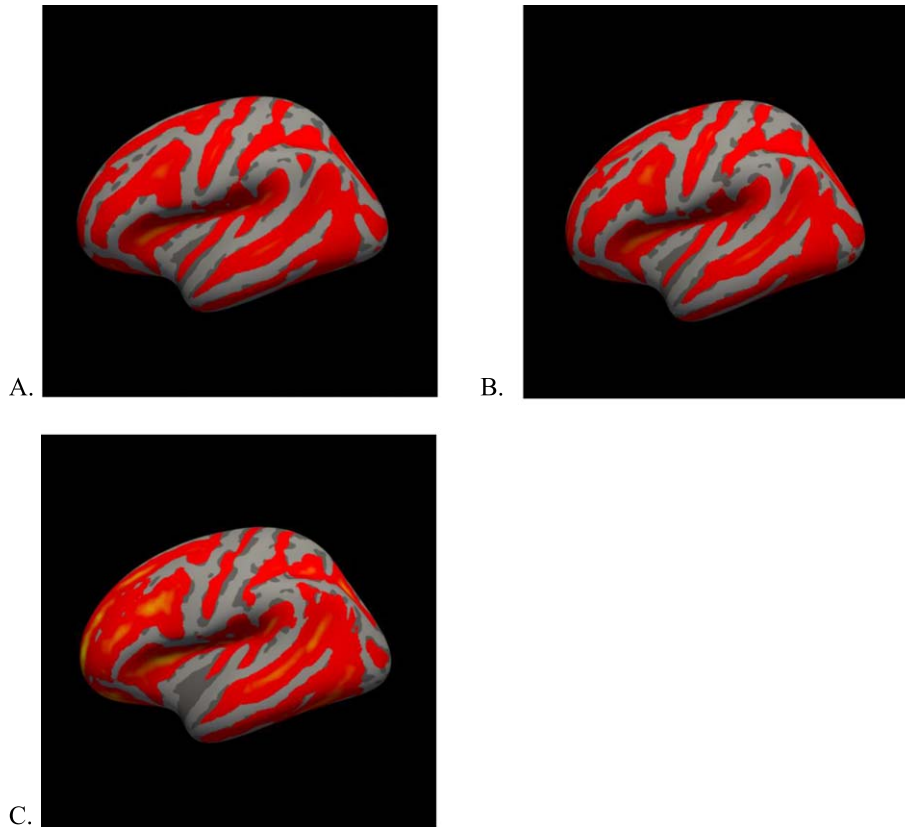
Surface-based representation of A $\beta$  burden measured by amyloid PET SUVR. In these images, dark grey represents cerebral sulci, light grey represents cerebral gyri, and red/yellow represent areas of greater than the 50th percentile of amyloid PET SUVR distribution, with yellow indicating greater uptake. A) NC subjects. B) MCI subjects. C) AD subjects. In all images, A $\beta$  largely accumulates in the cerebral sulci; with AD, A $\beta$  deposition becomes more prominent in the gyri of the frontal lobe. There was no visually demonstrable difference between males and females in this representation of A $\beta$  burden (separate male/female figures not shown).
